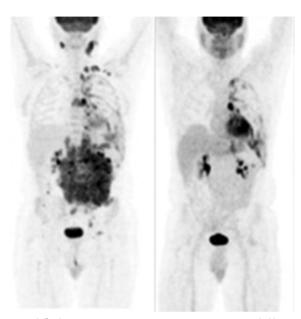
<sup>16</sup>FDG (fluoro deoxyglucose) PET volume [MIP] images pre-antiCD20 RIT demonstrating a very large abdominal lymphoma and smaller foci of nodal involvement in the mediastinum, left supra-clavicular area, left neck and right sub-mandular region. Repeat imaging at 5 ½ months demonstaring complete resolution of lymphoma activity. Persistant FDG-avid foci in the left chest represents granulation tissue from prior pleurectomy for tumor involvement. Patient is a 49 year old man who had been initially treated with CHOP in 1993; relapse in 1998 with a good response to rituximab. The patient was retreated with chemotherapy but relapsed in 2002 and again one year later.
